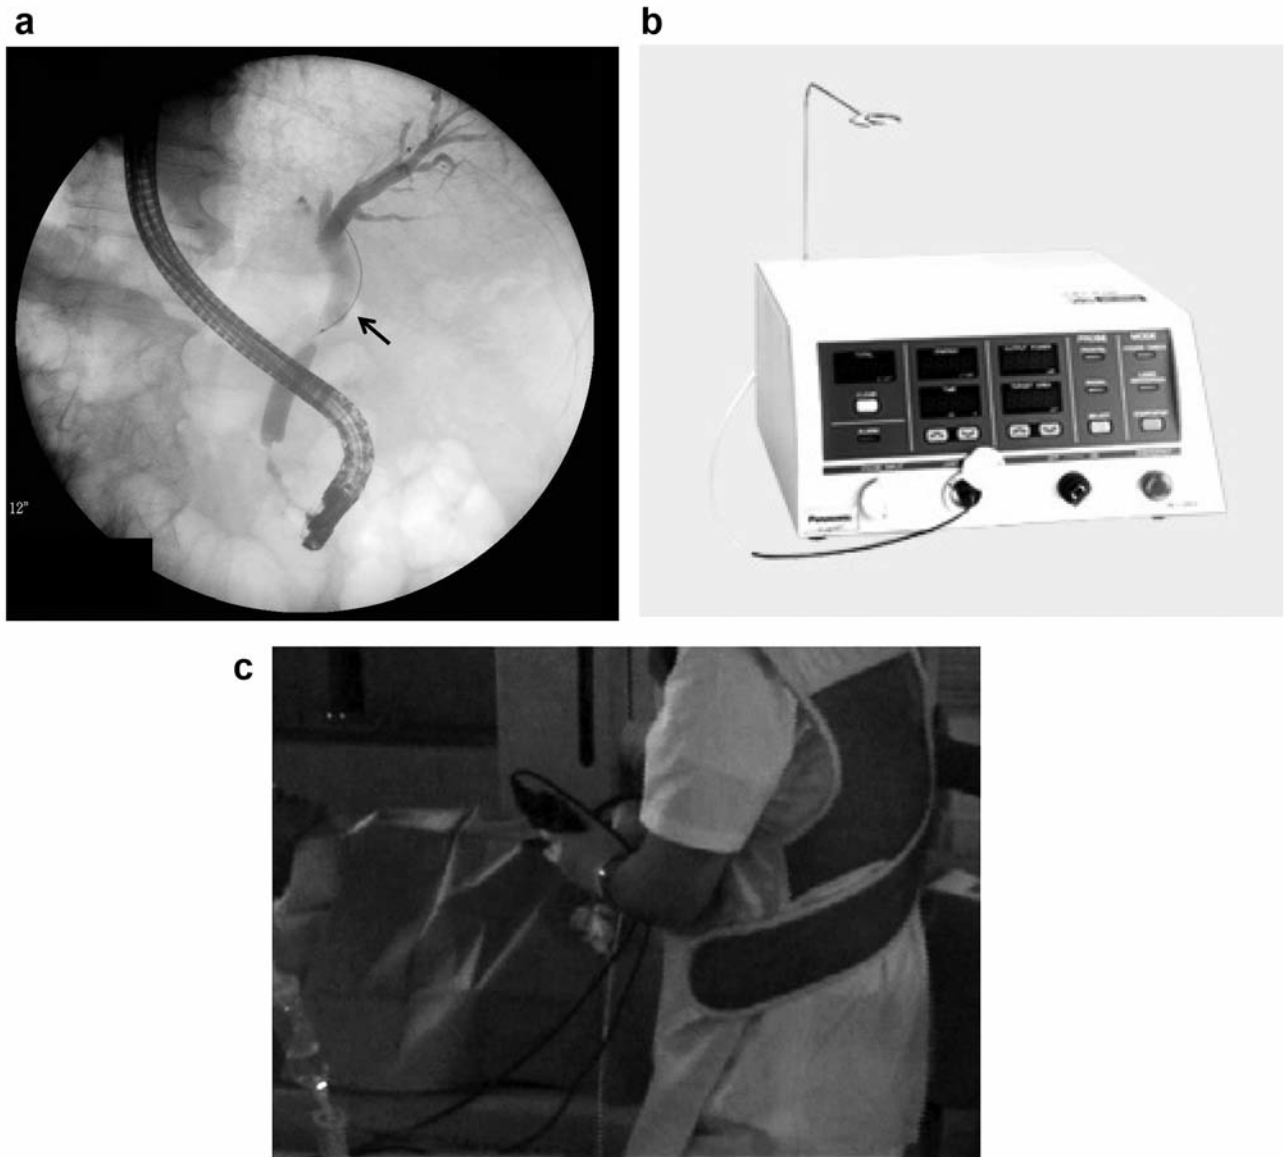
Talaporfin Sodium-Photodynamic Therapy (TPS-PDT). a): Placement of preload catheter via the papilla Vater using endoscopy and X-ray findings of laser catheter (arrow). The pusher tube was not detected by X-ray this Figure is taken from a Japanese publication (37). b): PDT semiconductor laser (ZH-L5011HJP; Panasonic Healthcare Co., Ltd., Tokyo, Japan). (Figure was referred from company's web site; <http://panasonic.biz/healthcare/pd/>). c): Approach for cholangioscopy via an abdominal wall fistula and anastomosed jejunum.
